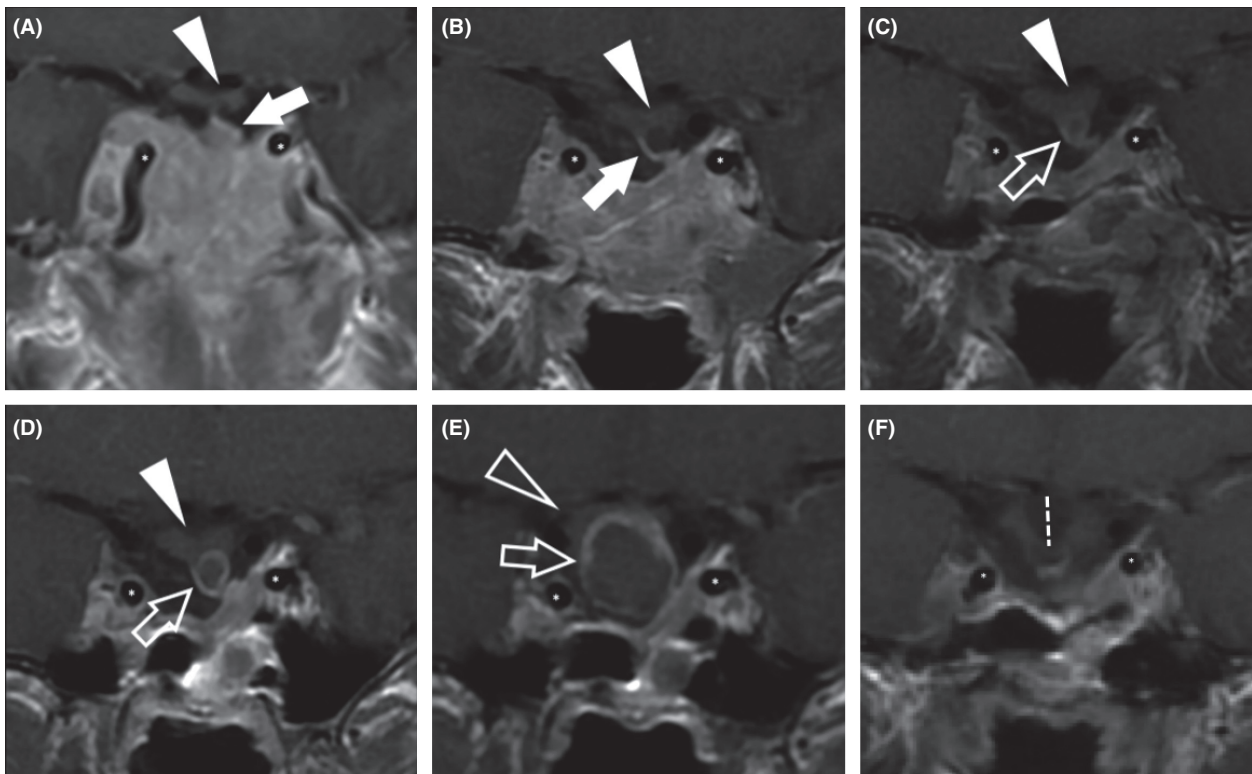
Magnetic Resonance (MRI) coronal image TSE - T1-weighted after administration of contrast material. In panel A, B, C, D, and E the images acquired in the first exam, after 2 months, after 7 months, after 14 months, and after 22 months, respectively, are given. The asterisks identify the carotid arteries in the supra-clinoid segment. In panel A, the caudal part of the infundibular stalk (white arrow) seems to be involved by the prolactinoma, whereas the optic chiasm does not show pathological signal (white arrowhead). There is also a complete encasement of the internal carotid artery. In the panel B, the infundibular stalk (white open arrow) does not show alteration, whereas in the panel C, a small (mm 3.2) hypointense mass with peripheral enhancement is observed; these are the typical features of a craniopharyngioma that become clearer in the panel D with a mass diameter of 5.7 mm and panel E with a mass diameter of 15.6 mm. In the panel E, the cranial dislocation of the optic chiasm is also visible (white open arrowhead). In the MRI check, acquired 2 months after the surgical procedure, there was no evidence of recurrence of pathology (panel F) but the herniation of the chiasmatic cistern into the sellar cavity is visible (white dashed line).
